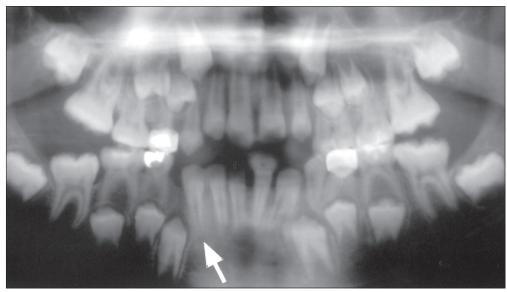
Panoramic radiograph after treatment—note enhanced eruption of supernumerary tooth
